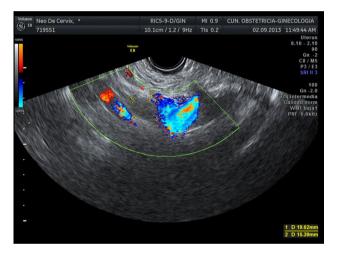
Transvaginal ultrasound depicting the internal iliac vessels. A suspicious lymph node measuring 19×15 mm is observed
